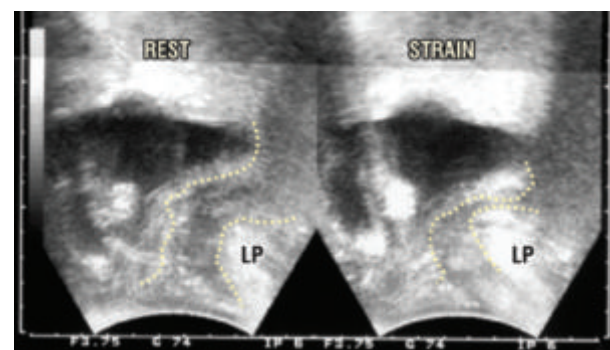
Post-operative perineal ultrasound, at rest and straining. Note restoration of normal anatomy. The anorectal angle is now essentially normal at rest. On straining, the rectum narrowed markedly just above the ano-rectal angle, with forward displacement of the anus, and creation of a more acute ano-rectal angle.
